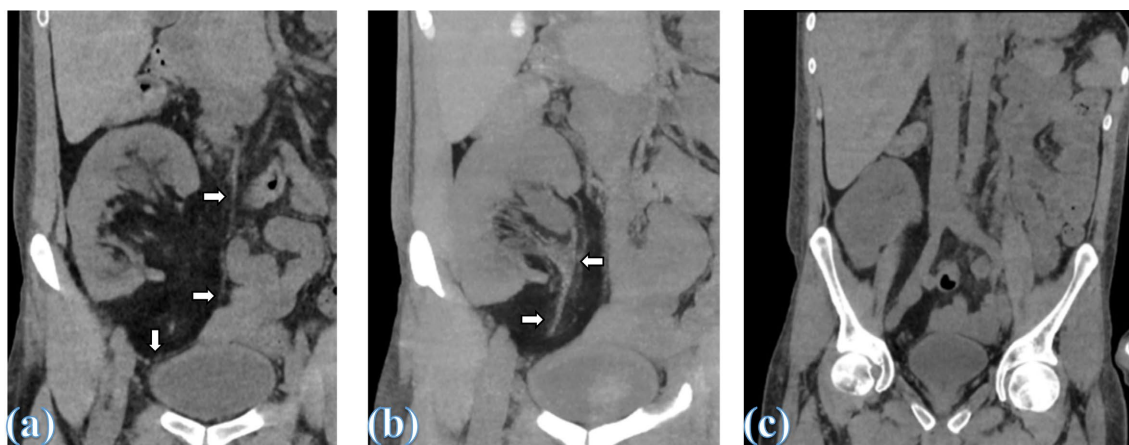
CT scan pictures of the pelvis showing: (a) a large homogeneous fatty tissue extending into its renal sinus and with an intact capsule (Arrows), (b) its encapsulation of the transplanted kidney pelvis and its ureter (Arrows), and (c) absence of iliac and para-aortic lymphadenopathy.
